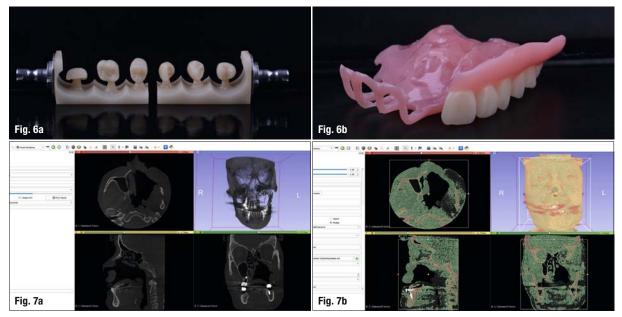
Milled teeth (milled using the CORITEC 140i, imes-icore). Fig. 6b: Printed denture. Fig. 7a: 3D image from CBCT data. Fig. 7b: Segmented hard and soft tissue using 3D Slicer software.
